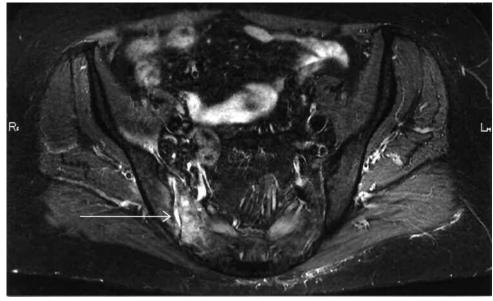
MRI of the SI joints: axial short-tau inversion recovery sequence.
